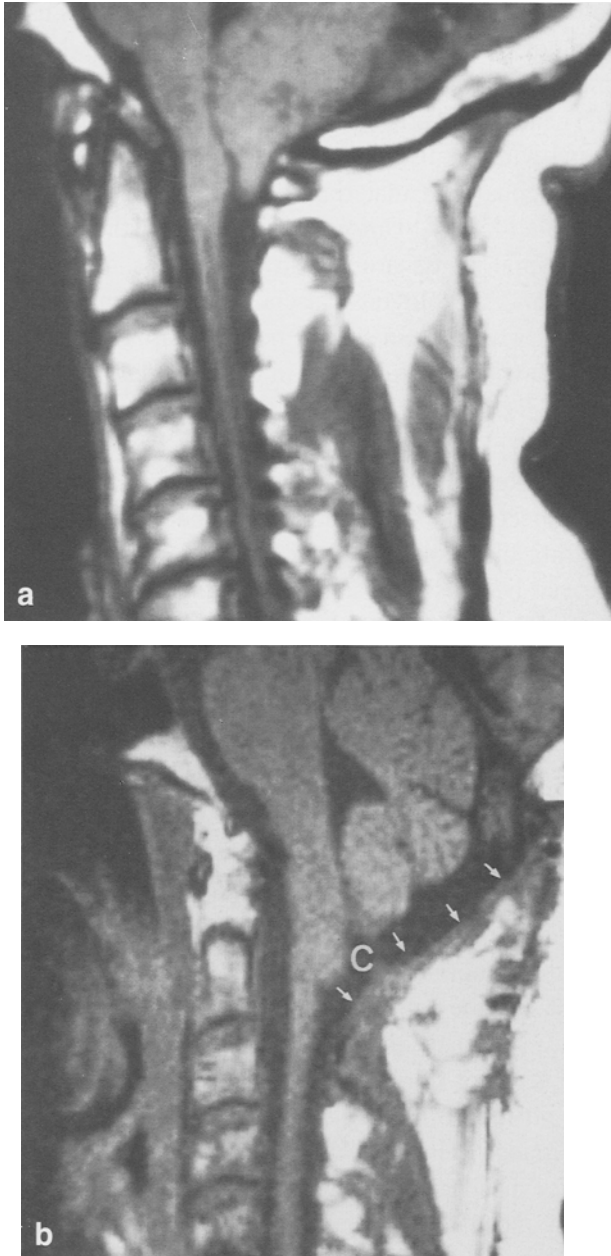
(a) Pre-operative sagittal T<sub>1</sub> MR imaging study of a patient with Chiari type I malformation. (b) Post-operative sagittal T<sub>1</sub> MR imaging study of the same patient shown in (a). The dural repair was performed with periosteum graft. There are neither subcutaneous fluid accumulations nor pseudomeningoceles. New cisterna magna (C). The arrows point at the periosteum dural graft
